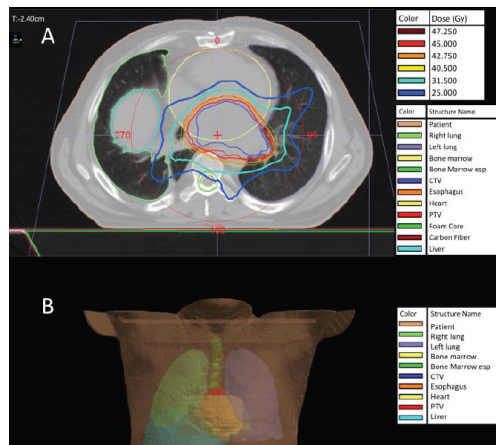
Images of RT treatment plan; (A) Target volume and OARs delineation with image registration between the planning CT scan and T1wCE Cardiac MRI Dose distribution: red, 100% of Total Dose (TD); orange, 95% TD; green, 30% TD; blue, 5% TD; (B) Three-dimensional visualization of the OARs and target volume for RT planning.
